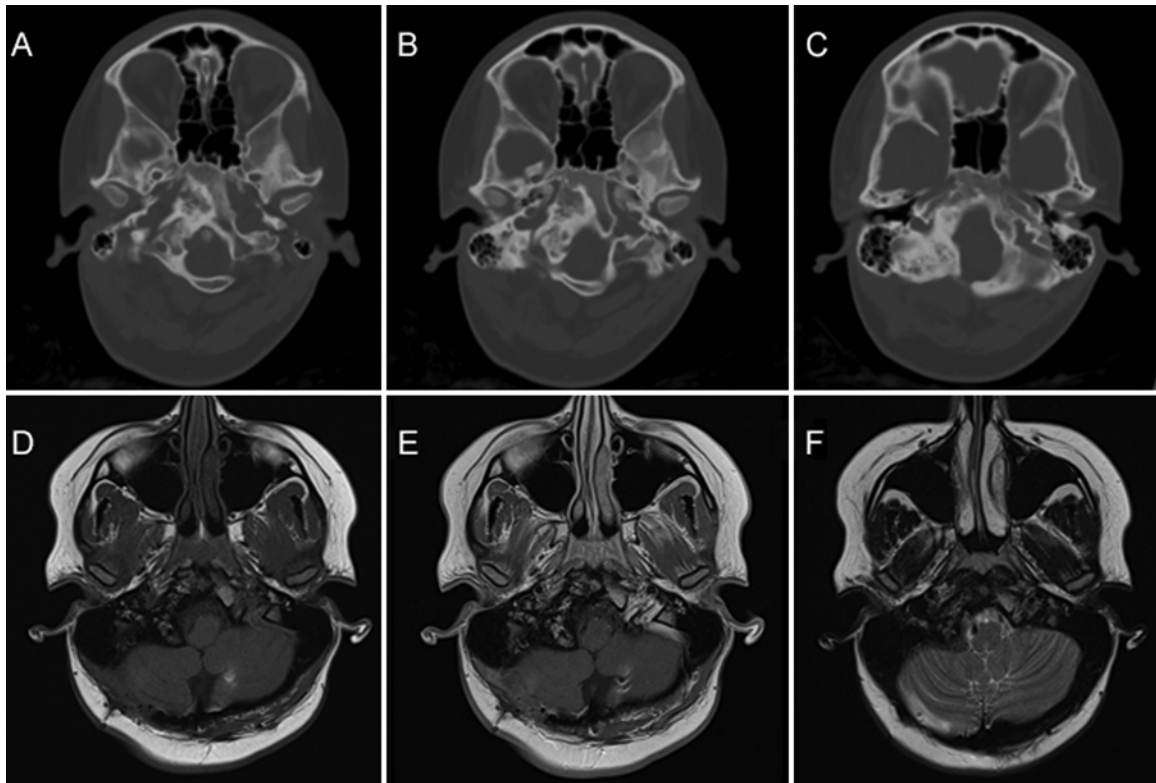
Follow-up when the patient was 19 years old, at 7 years after surgery and GKSRS. A–C: Unenhanced CT bone window serial slices demonstrating new bone formation with no aggressive features in the area of progressive residual ABC treated by GKSRS. D and E: T1-weighted precontrast (D) and postcontrast (E) MR images demonstrating normal bone marrow enhancement in the dysplastic temporal bone and occipital condyle. F: Normal low T2 signal in cortical bone with no evidence of recurrent fluid-fluid levels.
